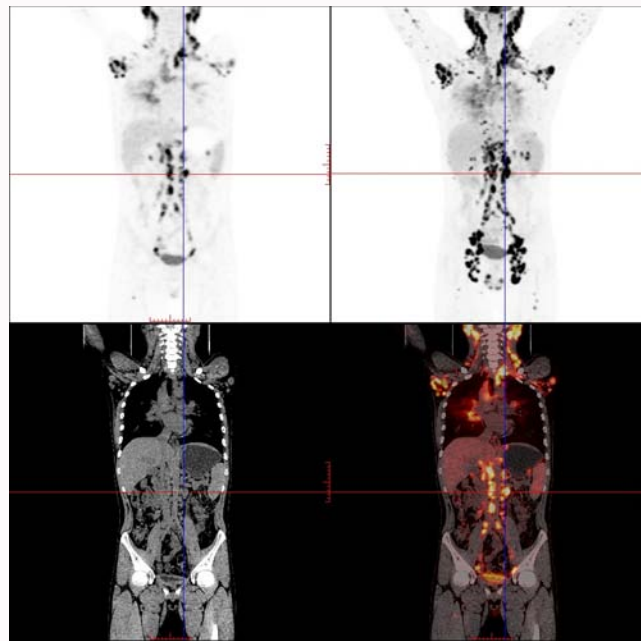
^{18}F -FDG PET/CT in a 25-year-old male with systemic TB: Systemic lymph node enlargement (SUVmax=16.8).
